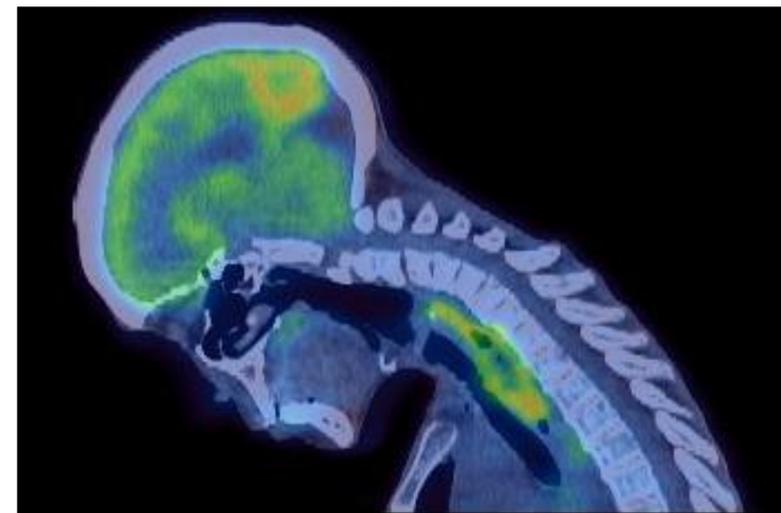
intense FDG uptake associated with oesophageal thickening
